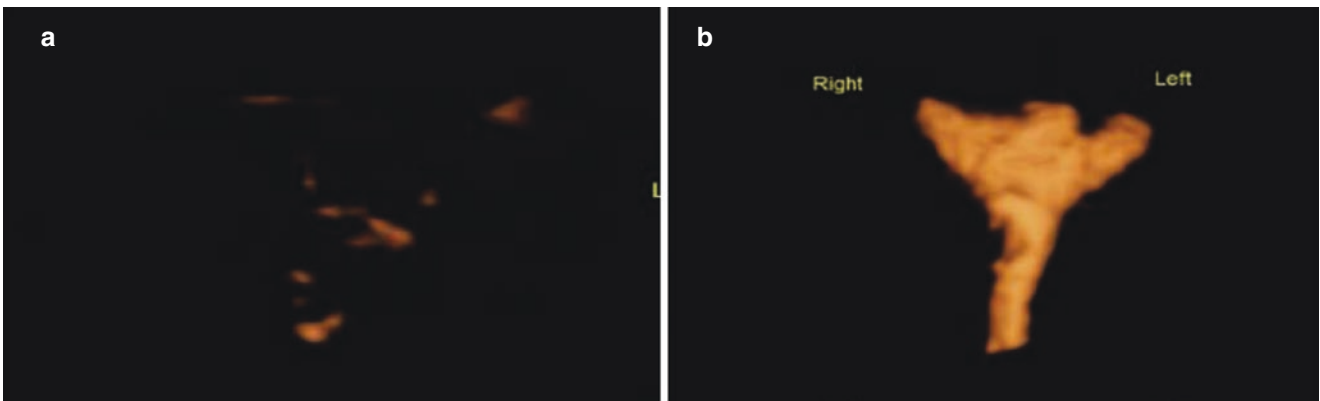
Salpingography of the obstructed fallopian tube (positive contrast agent). (a) There is almost no diffusion of contrast agent in the pelvic cavity; (b) 3-D ultrasound shows the obstructed proximal end of the fallopian tube
